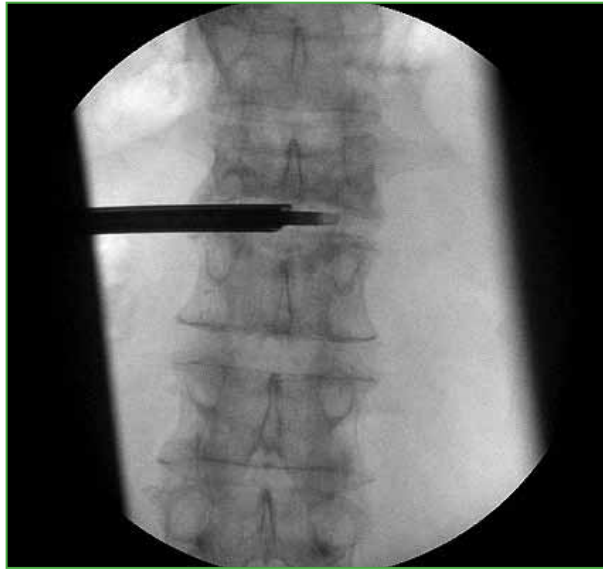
Anteroposterior radiographic projection. The placement of the endoscope according to the all-inside technique is observed.
